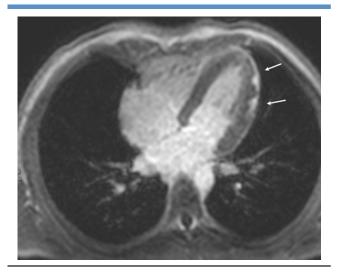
Cardiac magnetic resonance imaging, horizontal long-axis view, showing late gadolinium enhancement in the mid lateral and apical regions (annotated by *arrows*) with interval increased late gadolinium enhancement during the second episode.
